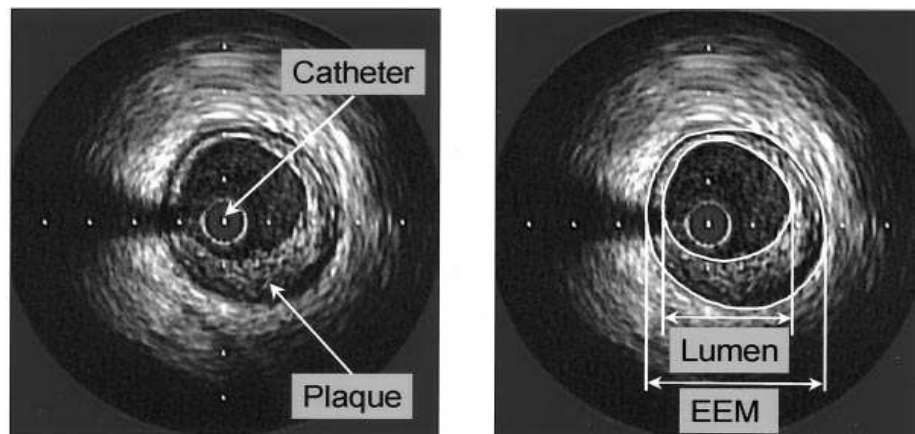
Intravascular ultrasound images show tomographic sections of the vessel, including lumen, vessel wall and adventitia (*Schoenhagen et al., 2001*)
